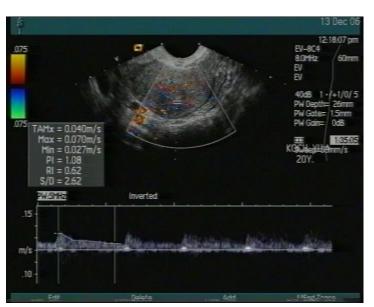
CDI and Doppler of the right uterine artery of patient K., 13 years old with primary dysmenorrhea.
